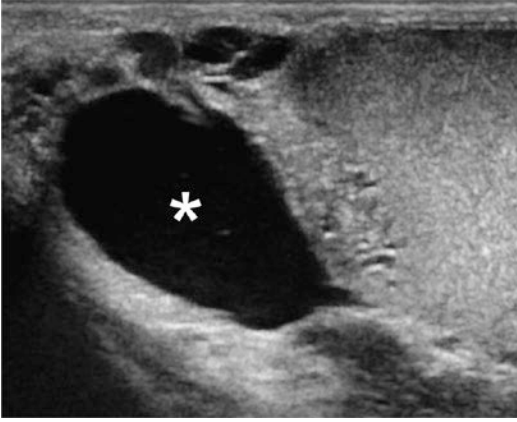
Epididymal cyst/spermatocele. Longitudinal ultrasonographic image showing an anechoic lesion with well-defined margins in the head of the epididymis (*asterisk*)
